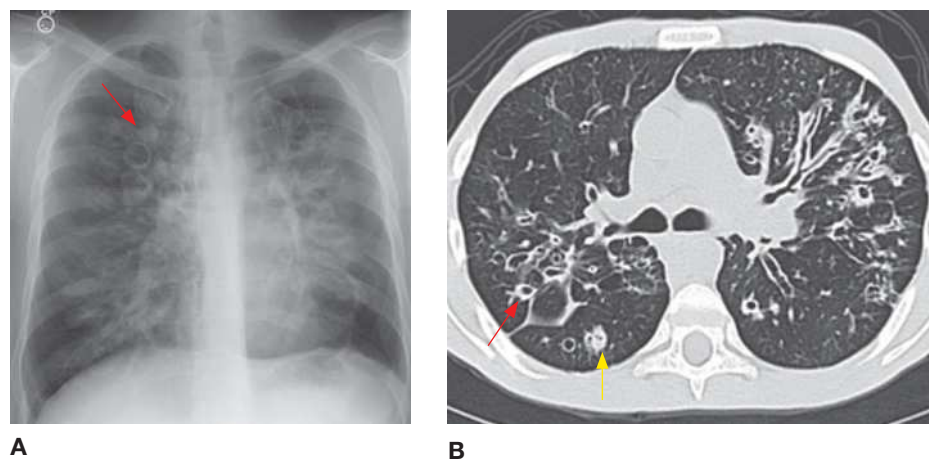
Cystic fibrosis. (A) Frontal CXR showing central cystic bronchiectasis (arrow) in a patient with CF. (B) Transaxial CT image showing cystic bronchiectasis (red arrow), with some bronchi containing impacted mucus (yellow arrow). (Reproduced with permission from USMLE-Rx.com.)
